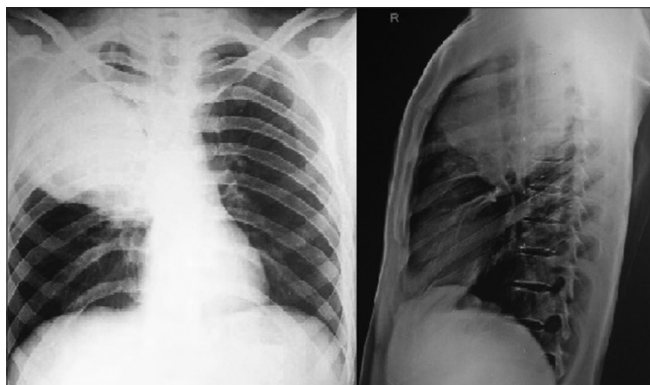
X-ray chest PA and right lateral view showing a large mass lesion at the right upper zone and rapid increase in lesion size compared to Figure 2
